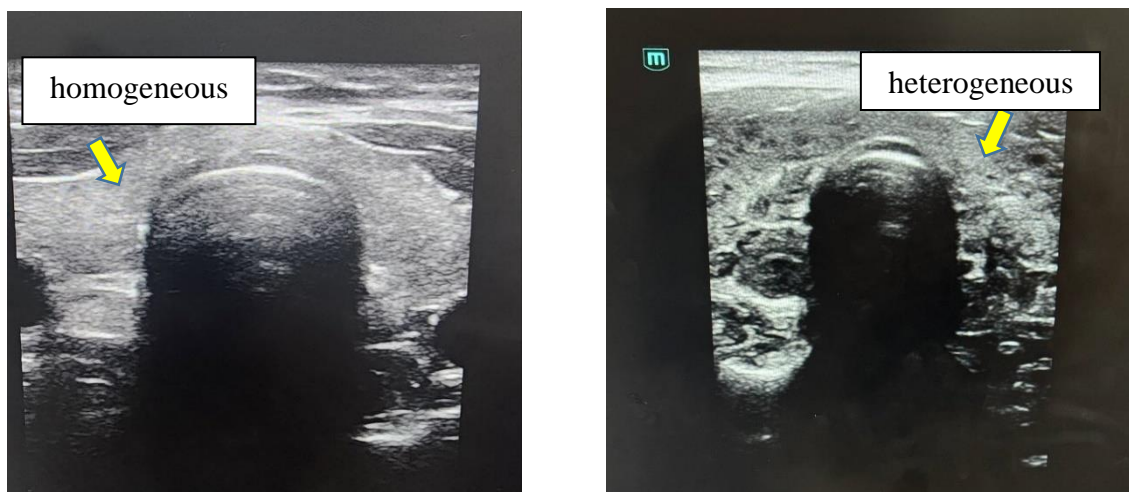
External appearance of the thyroid gland structure during ultrasound examination
